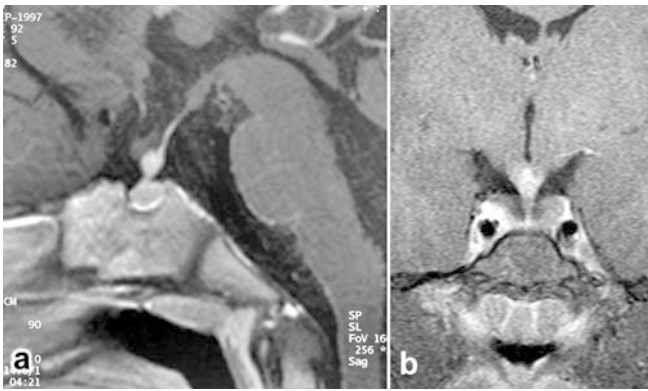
Cerebral MRI in a 1-year-old boy with diabetes insipidus owing to LCH shows nodular thickening and enhancement of the pituitary stalk on sagittal (a) and coronal (b) T1-W spin-echo sequences after IV gadolinium
